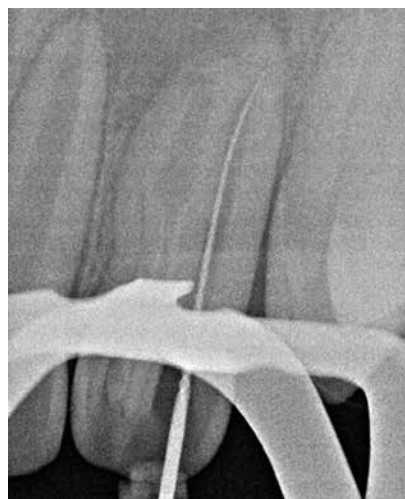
Periapical radiograph to determine working length.
